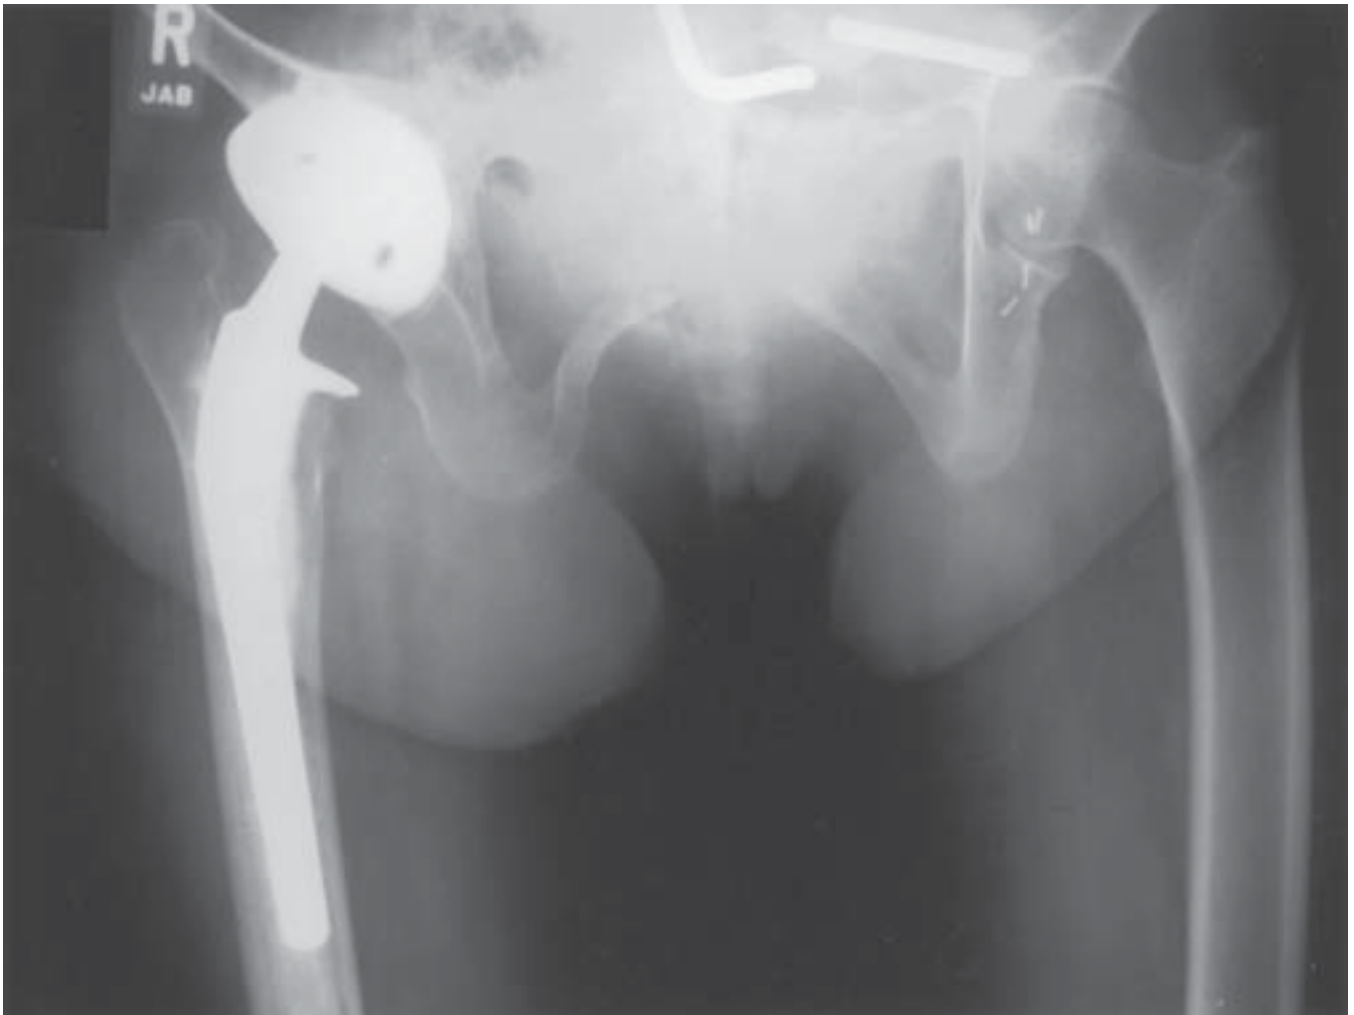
Anteroposterior radiograph of the pelvis after total hip replacement. Note left side Luque rod fracture.
